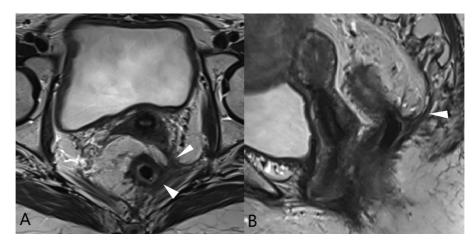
Response assessment magnetic resonance imaging (MRI) of patients with low-rectal cancer treated with long-course chemoradiotherapy (LCRT). (A) Axial and (B) sagittal T2 high-resolution (HR) MRI shows annular T2 hypointense posttreatment changes in the rectal wall. Sheets of T2 hypointense soft tissue along the left side of the rectum is seen contiguously thickening the mesorectal fascia (MRF) and loses plane with the left piriformis muscle (arrowheads).
